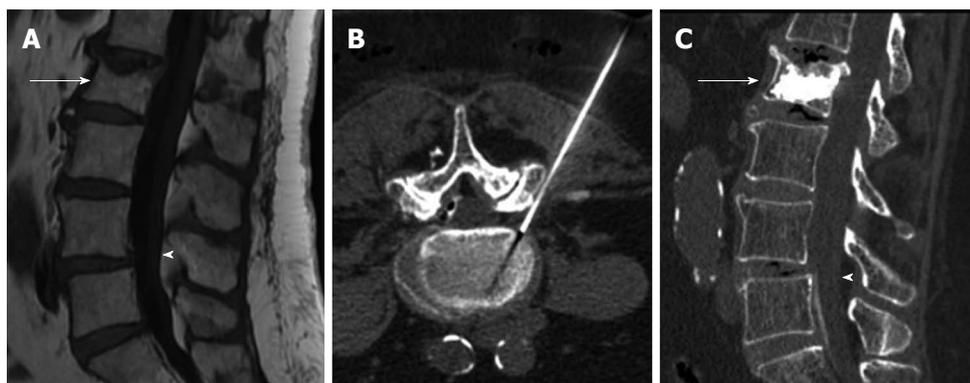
Sagittal T1 weighted image (A) showing vertebral compression fracture of L2 (arrow) and degenerative spondylolisthesis of L4 (arrowhead), computed tomography guided transforaminal epidural injection (B), Sagittal computed tomography after vertebroplasty (arrow) and epidural injection (arrowhead) (C).
